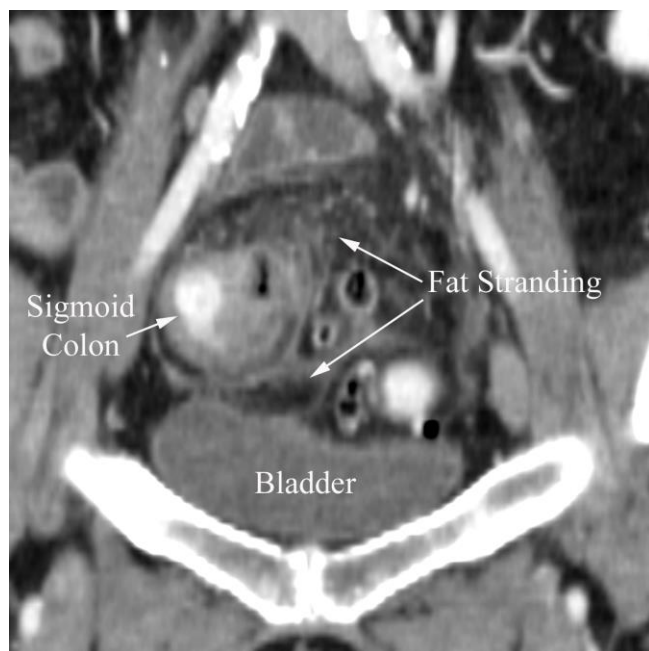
Diverticulitis in a 68 year old woman with urinary frequency and bacteriuria. Coronal reconstruction CT demonstrates the proximity of the urinary bladder to the inflamed loop of sigmoid colon, providing an explanation of the patient's symptoms.
